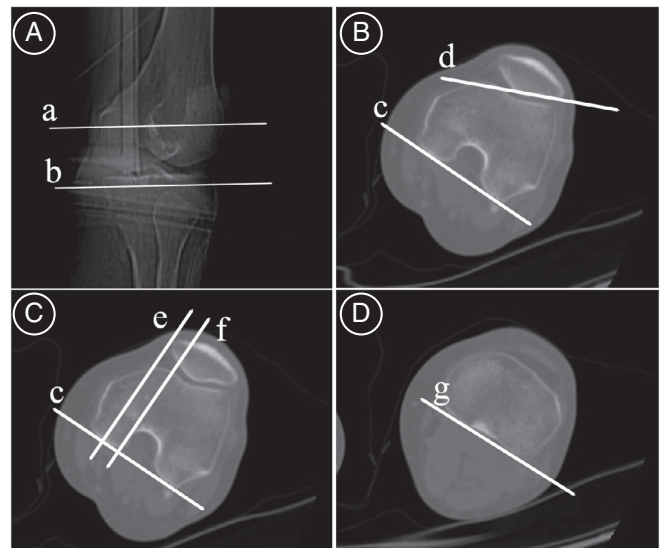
Tibiofemoral alignment measurement on computed tomography scans. A, The section showing maximum transverse diameter of the patella (a) was chosen for the definition of the lateral patellar facet (d) and the medial tip of the patella (f). The section just proximal to the fibula head (b) was chosen for the definition of the line connecting the two most posterior points of the tibia condyles (g). B, PTA is the angle between the slope of the lateral patellar facet (d) and the line connecting the two most posterior points of the femoral condyles (c). C, LPD is the parallel distance between the highest tip of the medial femoral condyle (e) and the medial tip of the patella (f), perpendicular to line c. D, TFR is the angle between the line connecting the two most posterior points of the tibia condyles (g) and line c.
